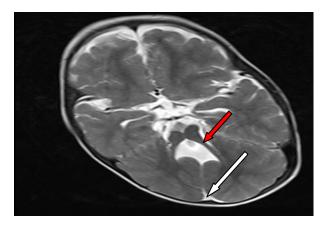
T2W axial MRI image showing bat wing appearance of the fourth ventricle (red arrow), vermian agenesis and extension of the cerebrospinal fluid cleft (white arrow) through it.
